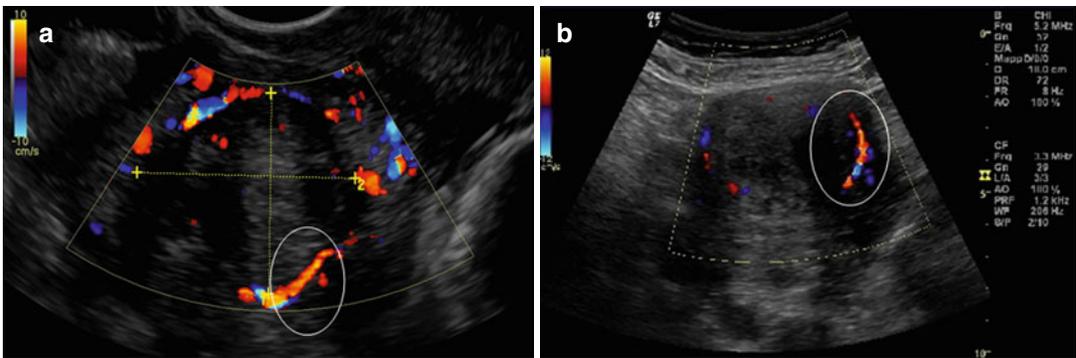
A uterine fibroid Doppler ultrasonography showing, in the *white ring*, the fibroid pseudocapsule as a “ring of fire” around fibroid (a, b, d); in the image (c), it is
